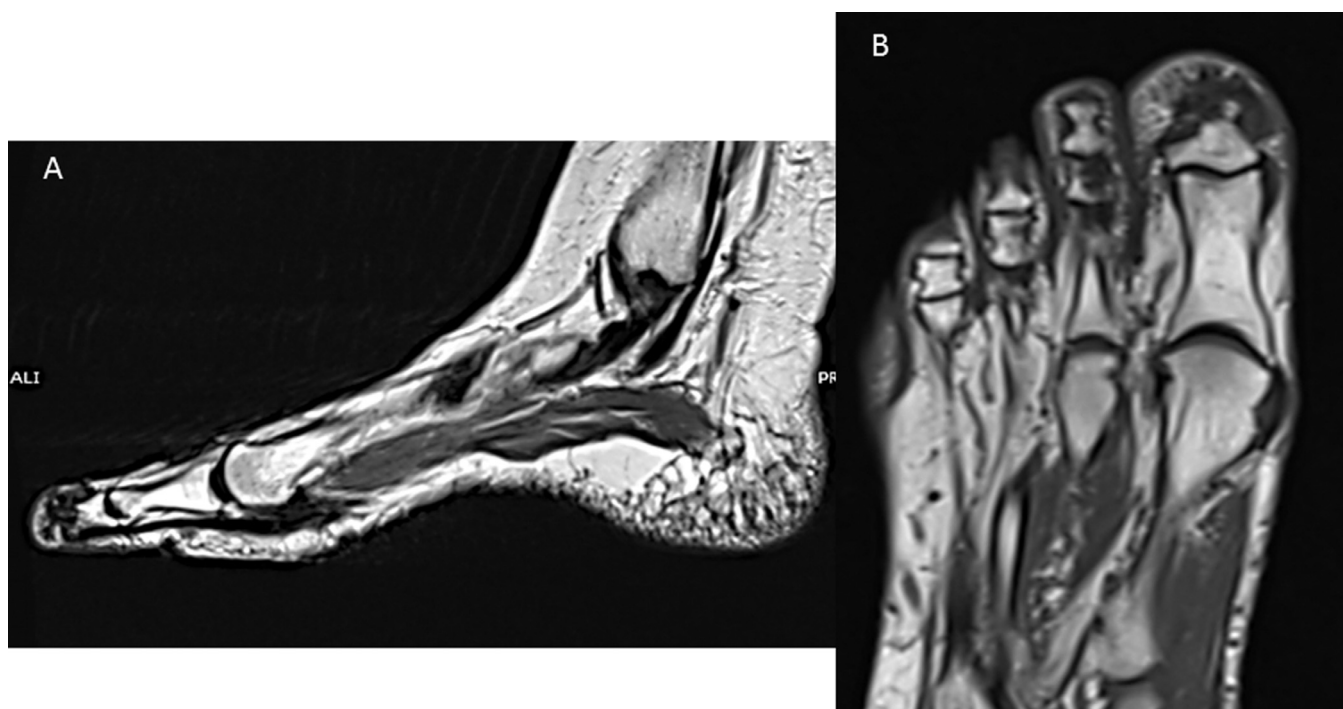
Axial and coronal MRI images shows edema in the soft tissue around of the bone stump of the distal phalanx (T1-weighted).
